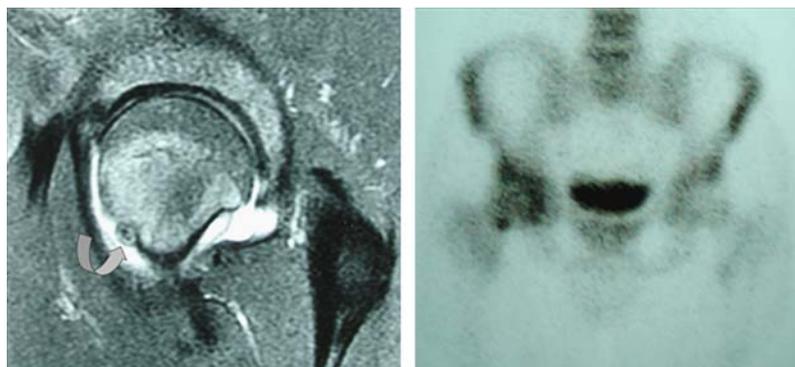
Patient 1. MRI and scintigraphy images of the right hip were consistent with osteoid osteoma in the anteromedial aspect of the femoral neck.
